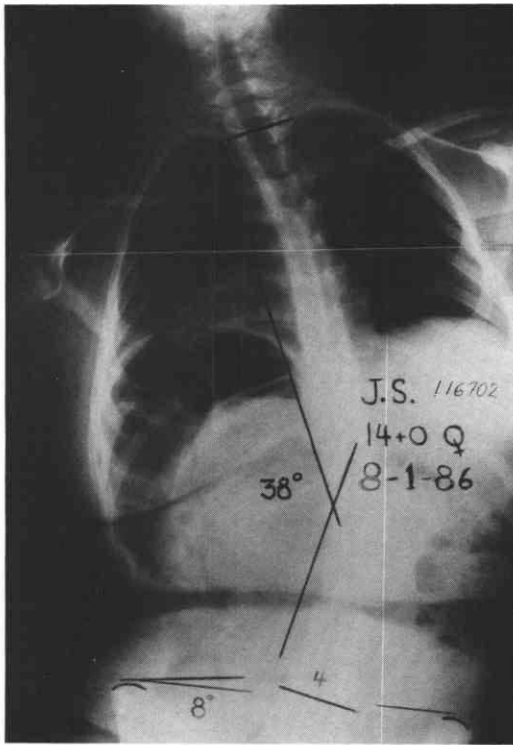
This x-ray of J.S., a 14 year old girl with cerebral palsy, presented with a pelvic rightward tilt of 8° and a convex-right thoraco-lumbar scoliosis of 38°. Her shoulders were tilted 13° degrees toward the left. Her clinical appearance verified the features noted on the x-ray. She occupied her right arm almost constantly as a lateral prop.
